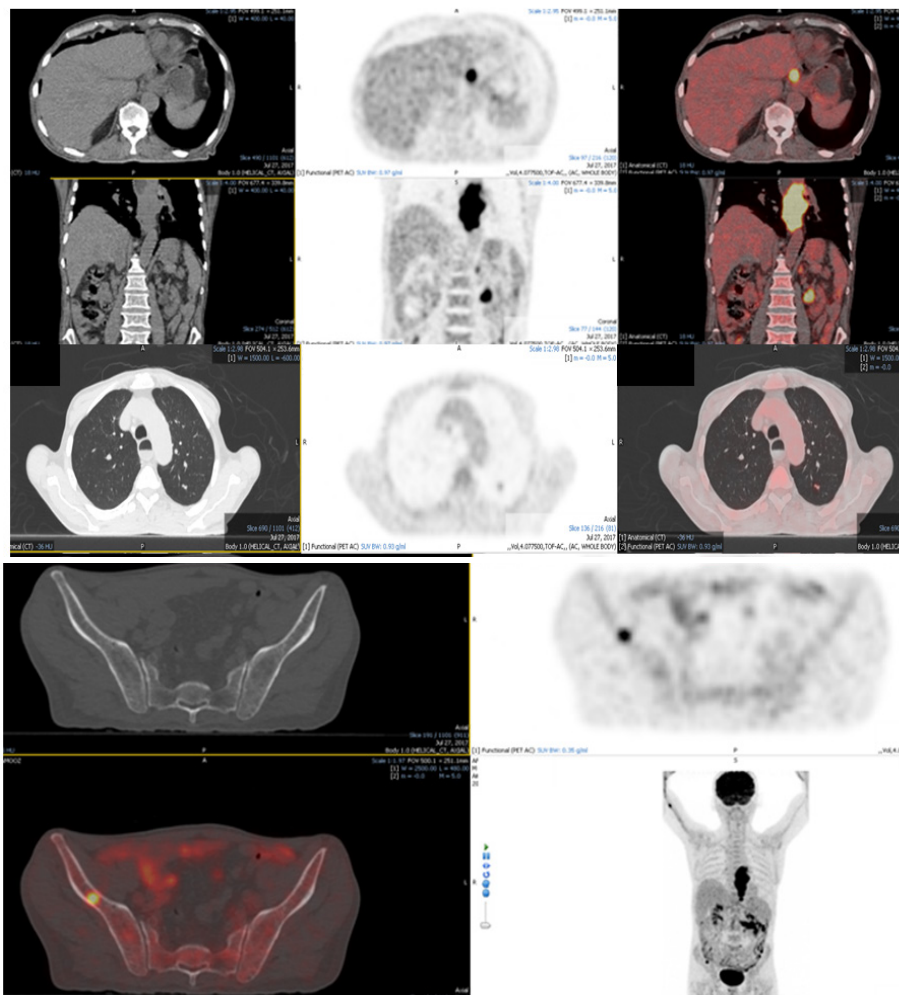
70 Years Old Male, Known Case of Esophageal Cancer, Baseline <sup>18</sup>F-FDG PET/CT for Staging Showing Hypermetabolic Circumferential Soft Tissue Mass Involving Esophagus from Carina to GE Junction (2nd and 5th rows), a hypermetabolic gastrohepatic lymph node (1st row), <sup>18</sup>F-FDG avid left pulmonary nodules (3rd row) and hypermetabolic left adrenal (2nd row) and solitary bony metastasis in right iliac blade (4th and 5th rows; Stage IV).
